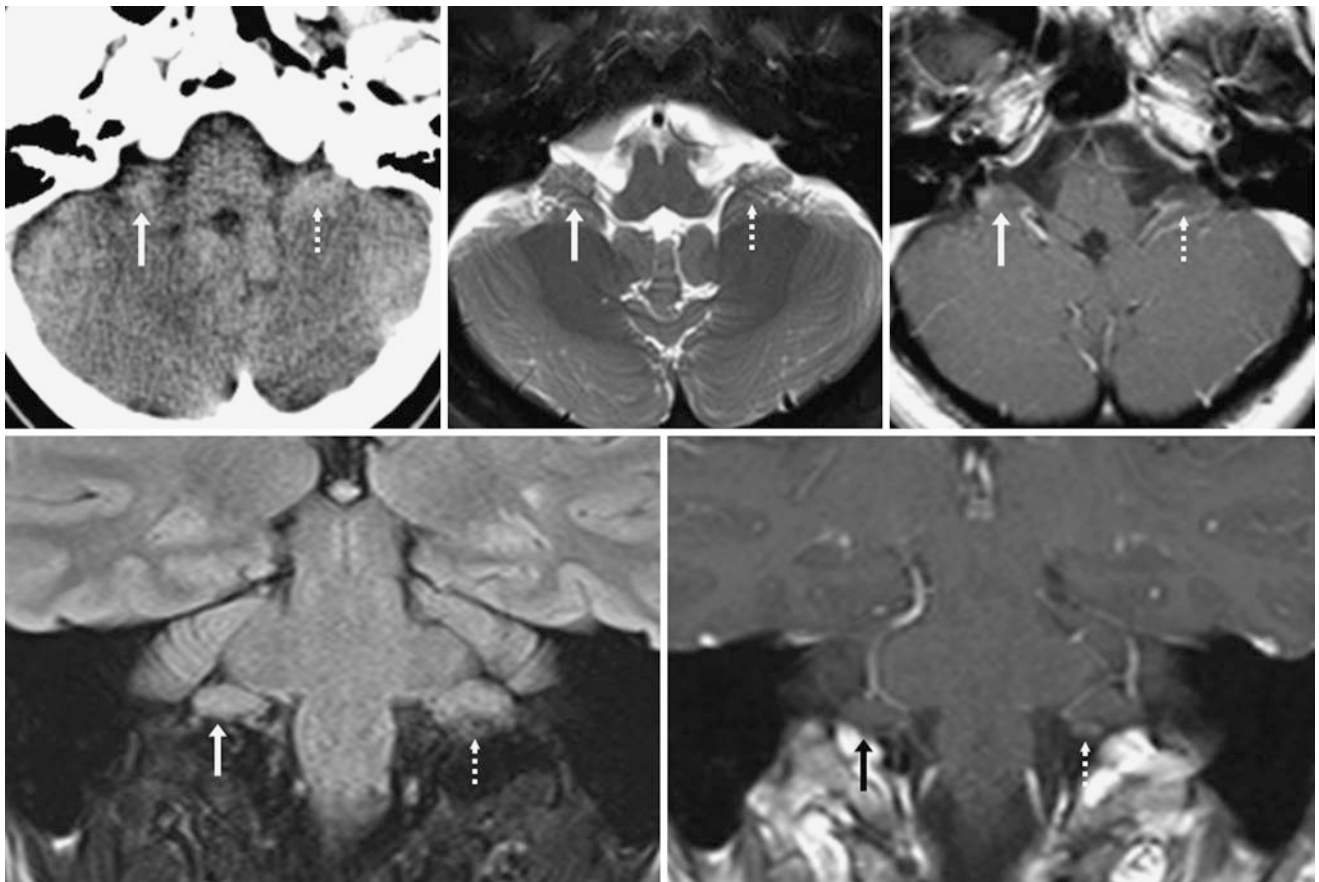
A 39-year-old patient with a suspected stroke (negative 3 T MRI). On NECT (*top left*) a right CPA apparent pseudomass (*arrows*) was questioned but was found to be the flocculus on axial T2WI (*top*
